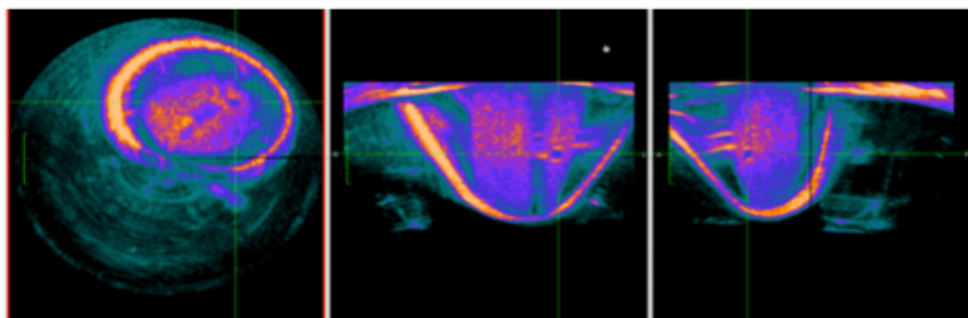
Colour mapping feature of three plane arrangement of the 3D ultrasound matrix data represented in DICOM.
